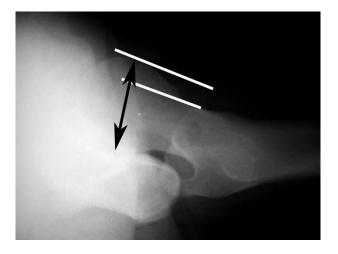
Cross-table lateral radiograph. White lines are along the femoral neck and parallel to the neck at the anterior margin of the femoral head. The black arrow indicates the total width of the femoral head. The ratio of the measured distance between the 2 white lines and the total head width is typically greater than 0.152 in anatomically normal hips. Numbers less than 0.152 indicate excessive posterior offset.16
